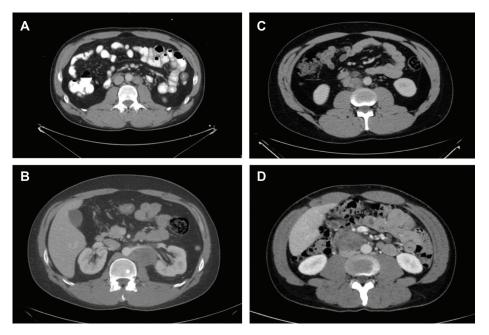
CT scans after first-line chemotherapy with seminoma and before salvage treatment. A and C, Patients were felt to be surgically resectable with minimal morbidity and were cured. B, Patient was expected to tolerate salvage chemotherapy poorly so elected to pursue surgery and was cured. D, Patient who was felt to require additional procedures during surgery and had high-dose chemotherapy.
